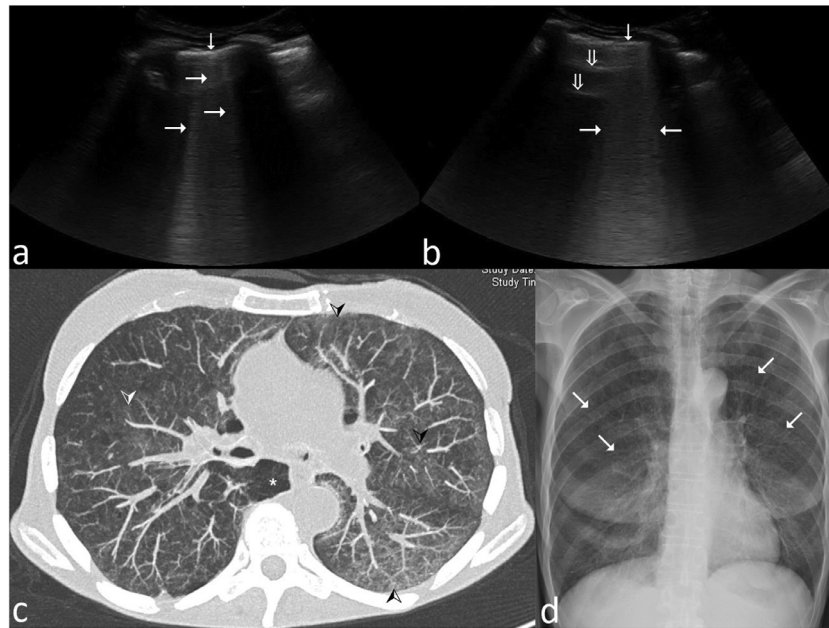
Lung ultrasound (LUS), computed tomography (CT) and chest x-ray (CXR) of a patient with *Pneumocystis jirovecii* pneumonia (PCP). a) and b) B-lines (horizontal arrows) are vertical, hyperechoic artifacts that arise from the pleural line (vertical arrows) and extend to the bottom of the screen. They move with respiratory efforts and obliterate horizontal imaging artifacts, so called A-lines (double arrows) that can usually be seen in the healthy lung and pneumothorax. Three or more (Lung and Interstitial Syndrome, 2010) B-lines per intercostal space correspond to thickening of interlobular septa, associated with edema, infectious disease or fibrosis. Separate B-lines (a) may merge with increasing interlobular thickening and (b), become indistinguishable (referred to as “coalescent”), which corresponds to ground glass opacities on CT (Lung and Interstitial Syndrome, 2010). c) Chest CT showing bilateral reticular markings, ground glass opacities (arrowheads) and emphysema (*). d) CXR showing bilateral perihilar reticular markings (oblique arrows). Note that the focal distribution of abnormalities can be assessed on CT (cross sectional imaging) and LUS (according to probe position), in comparison to the sagittal projection of CXR, which decreases the spatial resolution.
